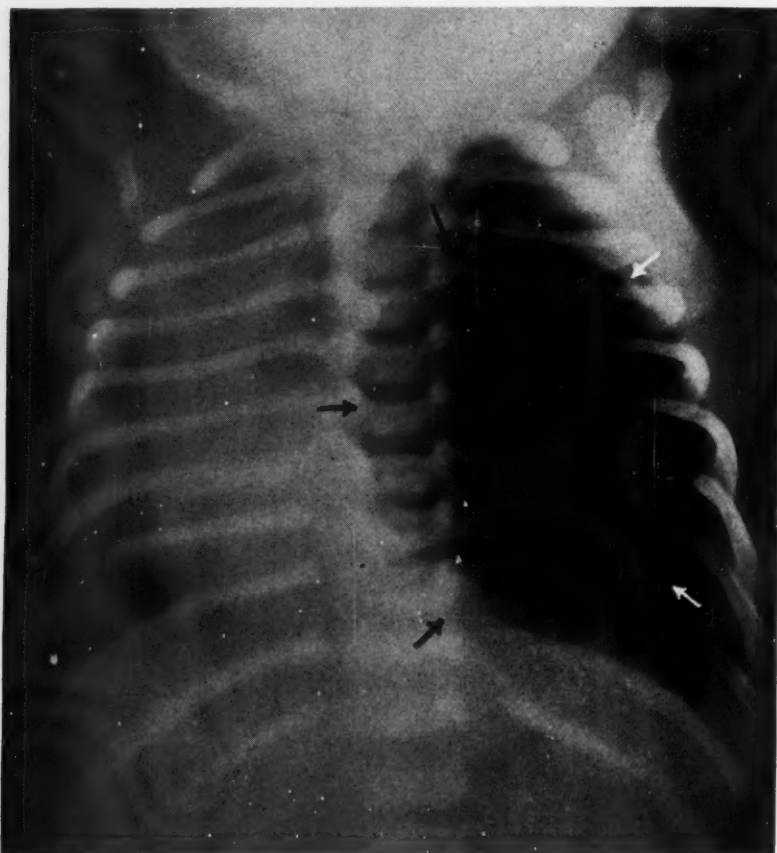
Preoperative roentgenogram of the chest, showing large cyst in the left lung, marked displacement of the heart to the patient's right, and compression of the right lung. (Cyst indicated by arrows)
